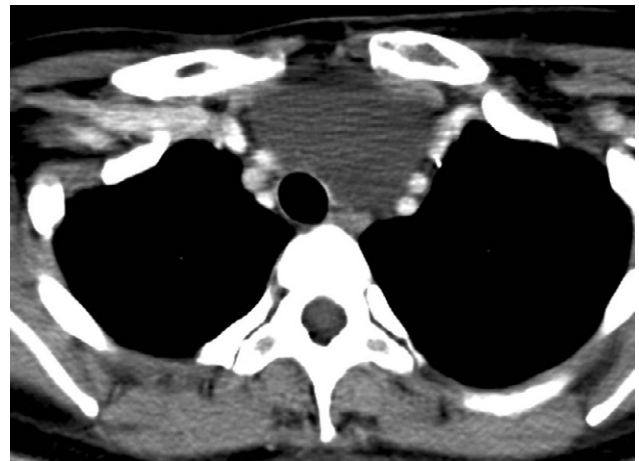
Computed tomography of the neck with contrast enhancement revealed a thin-walled cyst at the anterior mediastinum with lateral and posterior displacement of the trachea, esophagus and greater vessels.
